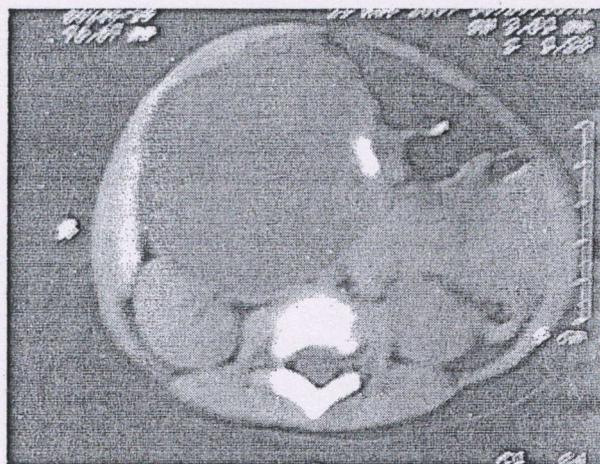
Case 2—CT scan depicting mass in the abdomen without any calcification
